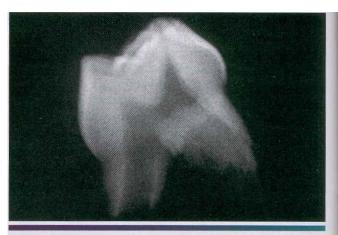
Vitamin D-resistant rickets. This radiograph of an extracted tooth shows a prominent pulp chamber with pulp horns extending out toward the dentinoenamel junction.
